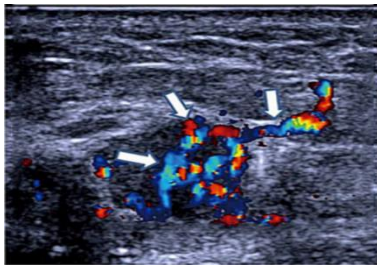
Some ultrasound features of breast cancer. Opal ligament thickening(arrow) in breast cancer on color Doppler flow imaging.
